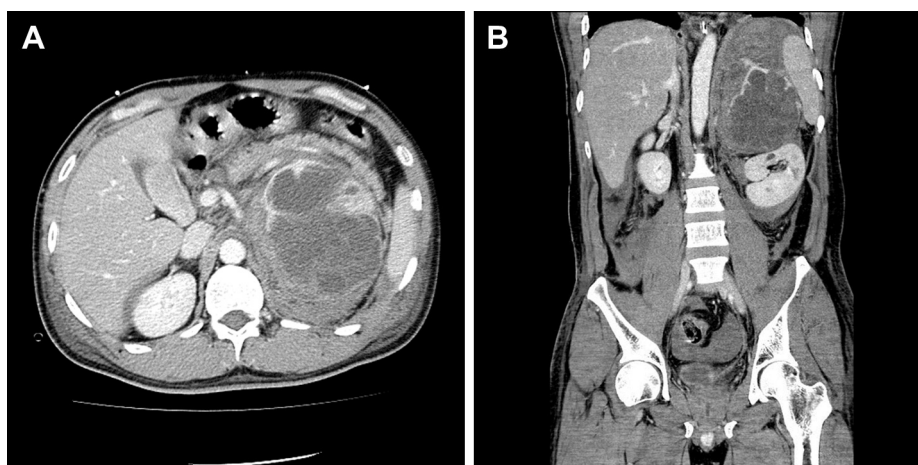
Preoperative computed tomography findings showed the left adrenal lesion with enhancement and large hemorrhage: (A) transverse plane and (B) coronal plane.
